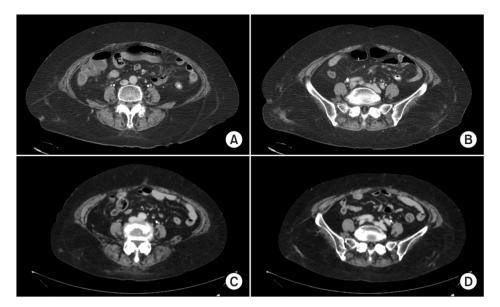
Computed tomography scan shows the inferior vena cava and right common iliac vein immediately after the procedure (A, B) and 5 years later (C. D).
